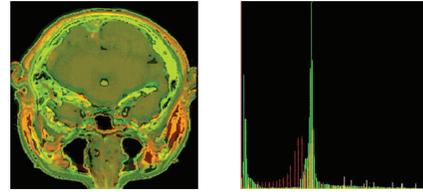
Overlap of CT (green) and transformed MRI (yellow) scans and intensity profiles after histogram permutation and matching. Red indicates the original MRI image and profile. The yellow intensity profile (transformed MRI) is a better match than the red intensity profile (original MRI) to the green one (CT scan).
